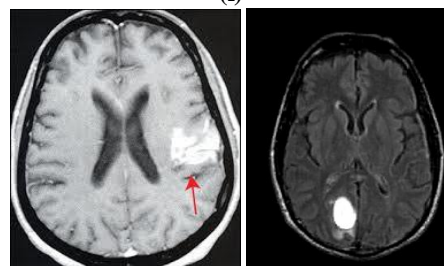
Sample brain MRI normal and abnormal images
